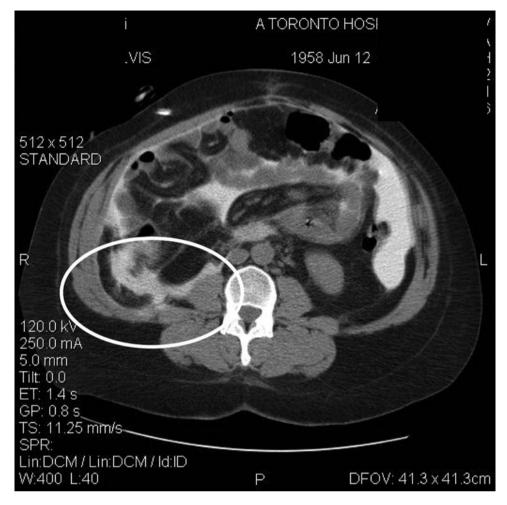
Advanced acquired cystic disease of the kidneys shown by CT scan. This long-term PD patient had small, shrunken kidneys at the start of dialysis. Reproduced from [330], with permission
